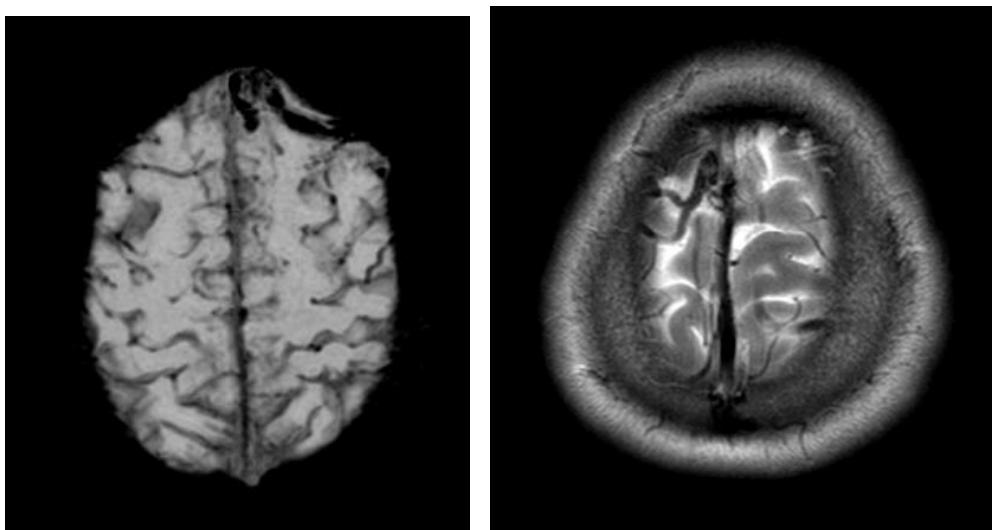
a) SWI image showing blooming in the anterior aspect of superior sagittal sinus and adjacent cortical vein b) Contrast MRI image showing filling defect in anterior aspect of superior sagittal sinus. Adjacent cortical vein thrombosis is better seen on the gradient images in (a)
